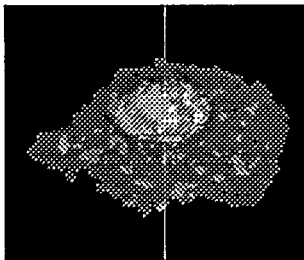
3-D pinhole SPECT
